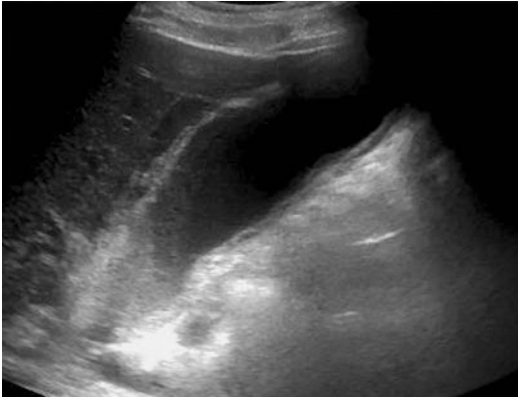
Ultrasound of the gallbladder with a thickened perihepatic gallbladder wall, pericholecystic fluid, and sludge in the neck of the gallbladder in a patient with cholecystitis
